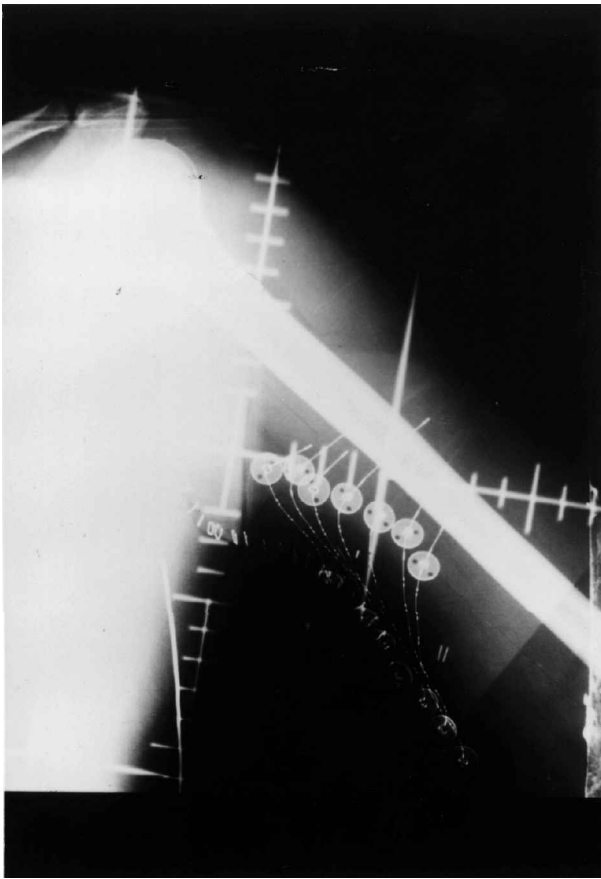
Radiograph of a single plane implant in the left arm with dummy metal sources for localization and dosimetry.
